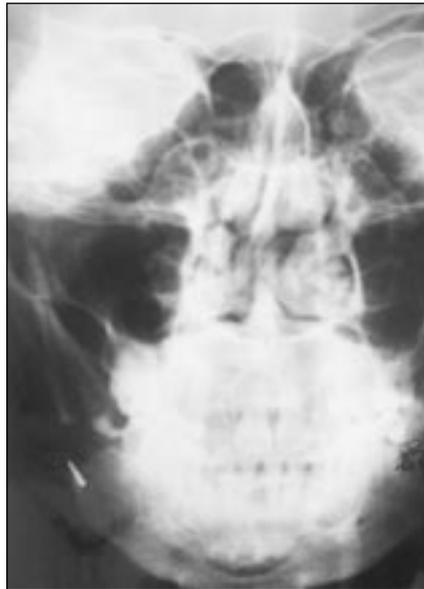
A postero-anterior skull radiograph which clearly defines the location of the foreign body at the inferior border of the mandible.
